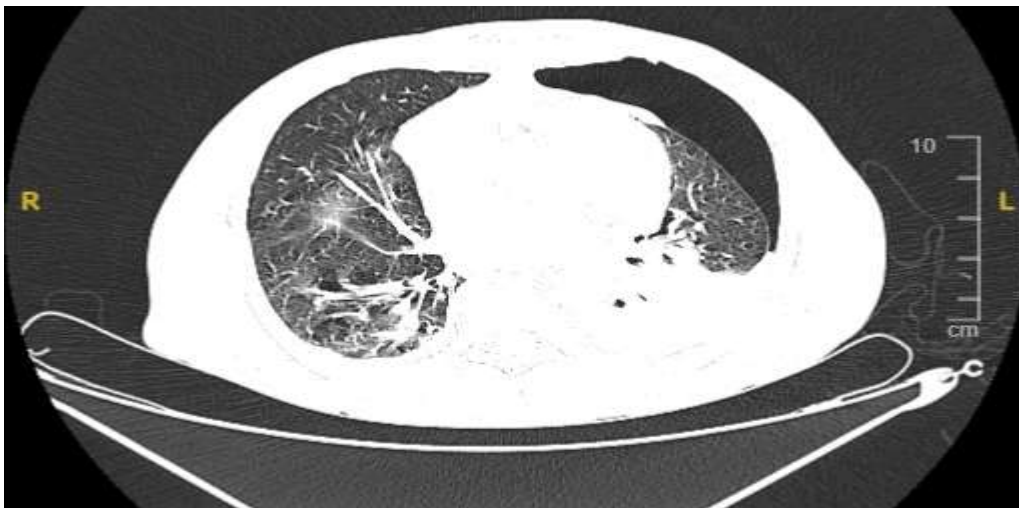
CT pulmonary angiogram showing moderate left hydropneumothorax
